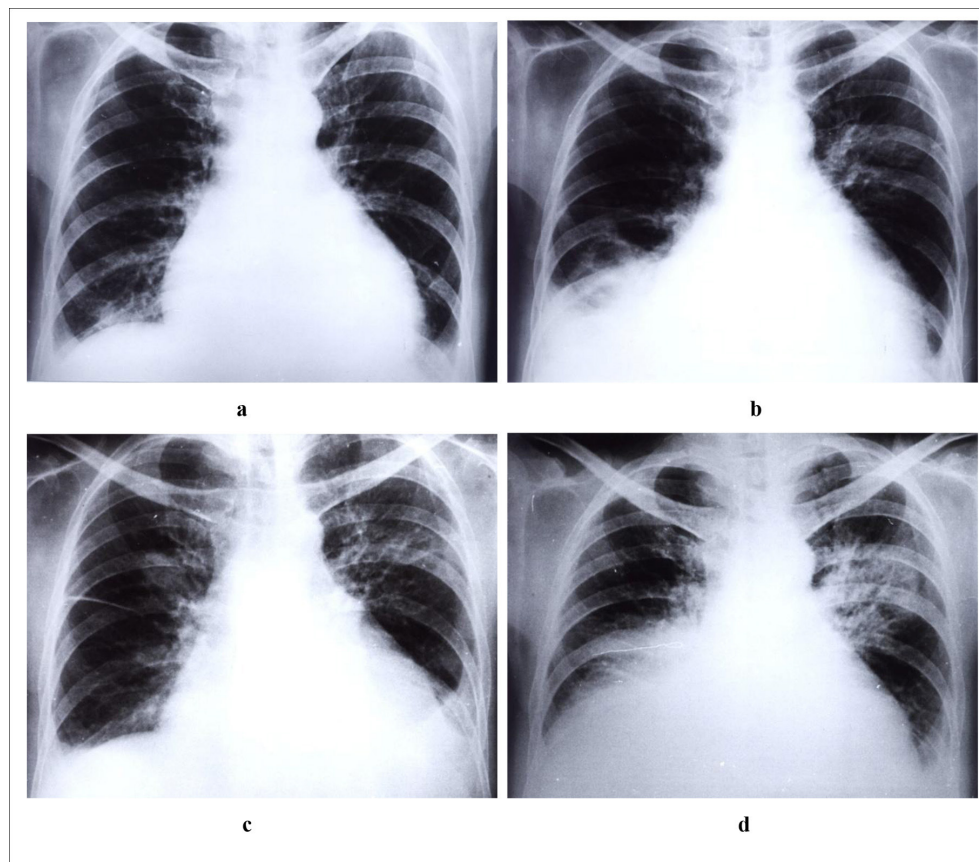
Chest radiograph (a) 25.08.1976, cardiomegaly (b) 28.09.1976, migrating pneumonic infiltrates (c) 15.10.1976, migrating pneumonic infiltrates (d) 29.11.1976, migrating pneumonia, hydrothorax
